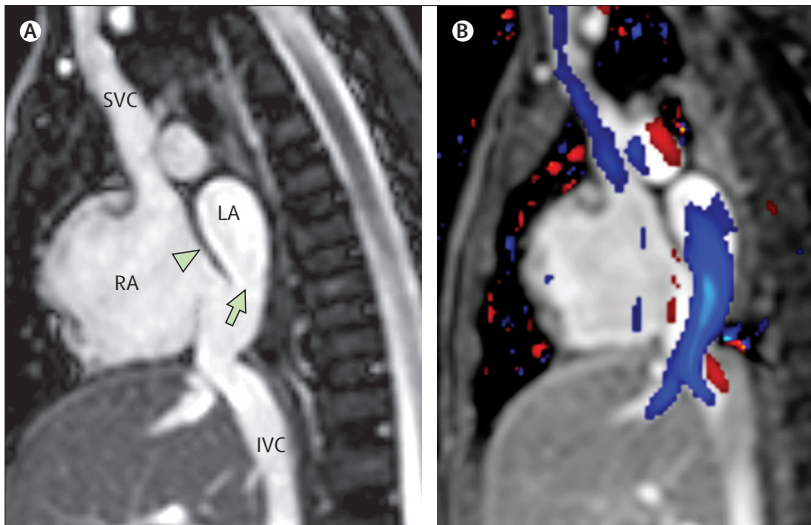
Inferior sinus venosus defect imaged by cardiac MRI
